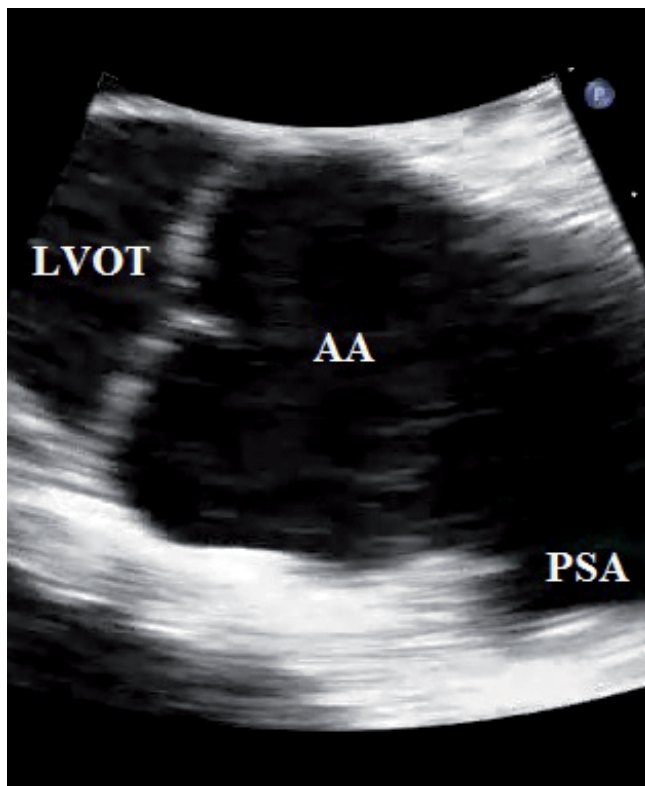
Transesophageal echocardiogram demonstrating the ascending aortic pseudoaneurysm. LVOT = left ventricular outflow tract; AA = ascending aorta; PSA = pseudoaneurysm.
